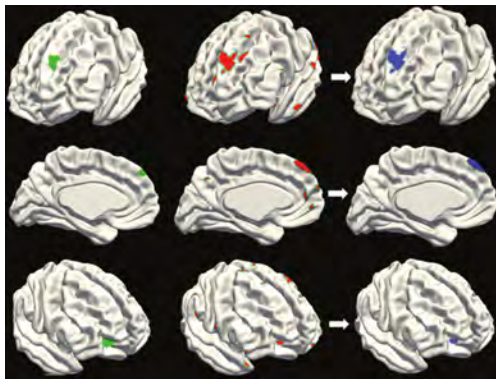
Surface projections for three MRI-negative patients. Manual lesion labels are shown in green, vertex-wise classification highlights multiple candidates in red, and cluster-wise refinement removes false positives, leaving only the cluster that aligns with the manual label in blue.
